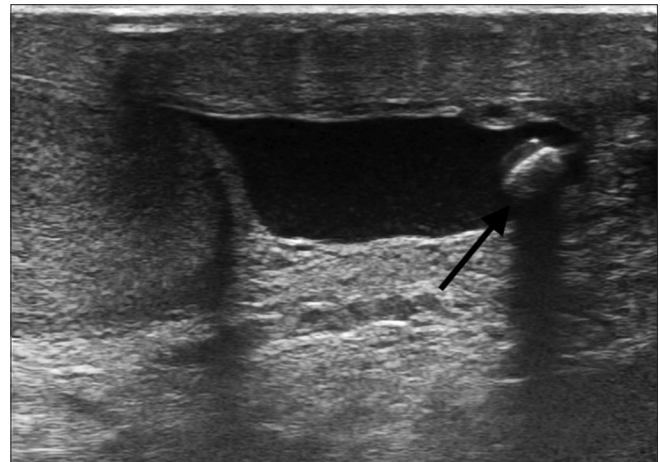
Grayscale ultrasonography image of the left scrotal sac shows free fluid and a hyperechoic structure with posterior acoustic shadowing
